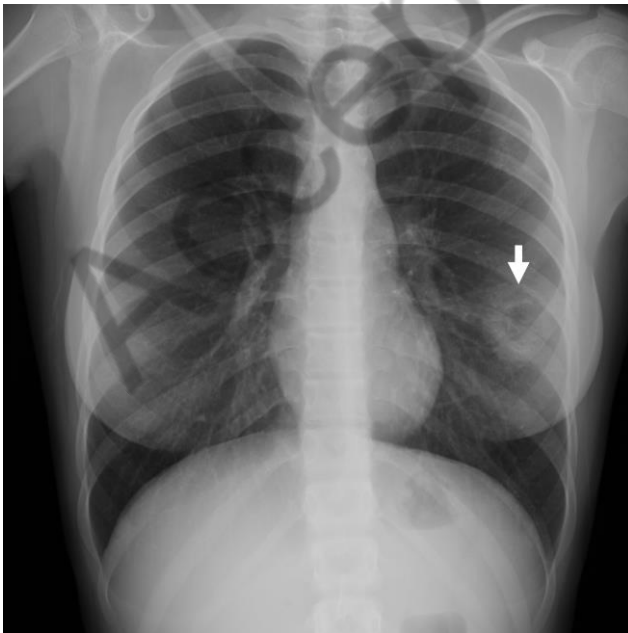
Chest radiograph (anterior posterior) showing reversed halo sign (arrow) in the left lung
